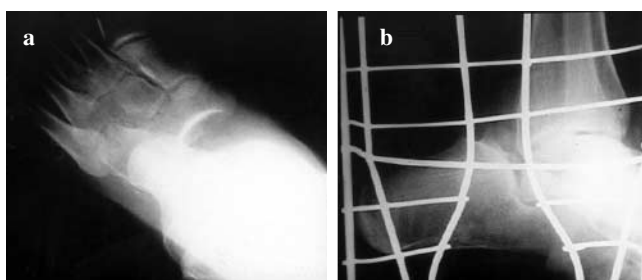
Case 3. Anteroposterior (a) and lateral (b) radiographic views of a medial subtalar dislocation
